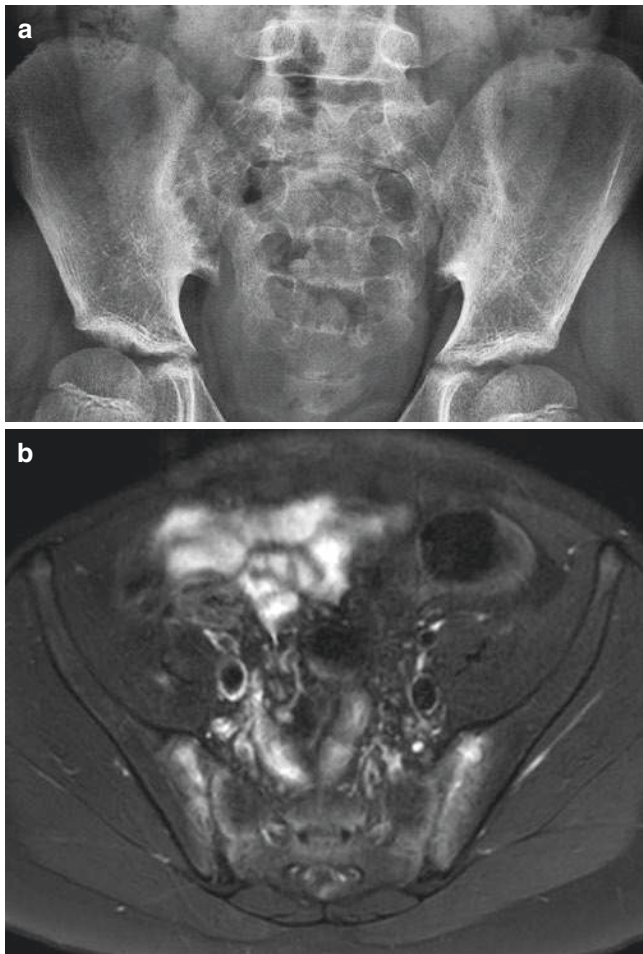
Twelve year-old boy with juvenile spondyloarthritis. (a) Anteroposterior radiograph shows symmetric widening and ill definition of the sacroiliac joints. Mild sclerosis is seen on the iliac side of each joint. (b) Axial T2-weighted MR image (TR 3,403 ms, TE 65 ms) shows synovial hypertrophy in both sacroiliac joints with irregularity and adjacent bone marrow edema
